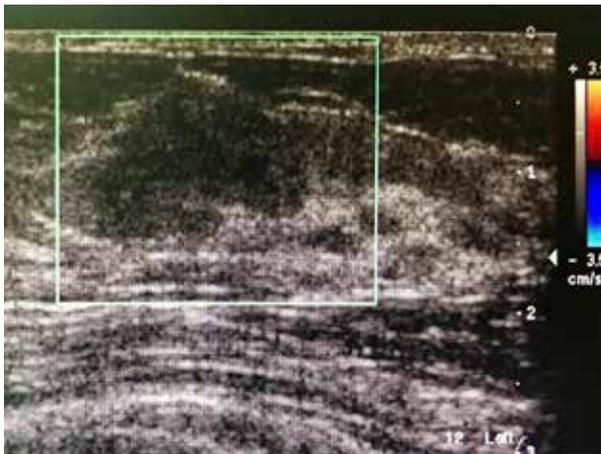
Doppler ultrasound of left breast mass with no vascular activity (Case 1)
